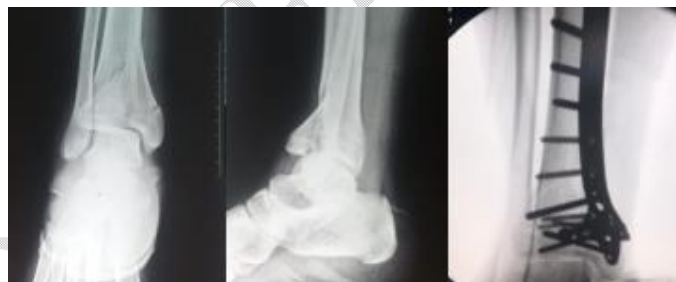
x-ray of the ankle front and profile showing a complex fracture of the tibial pilon treated with a trefoil plate.
